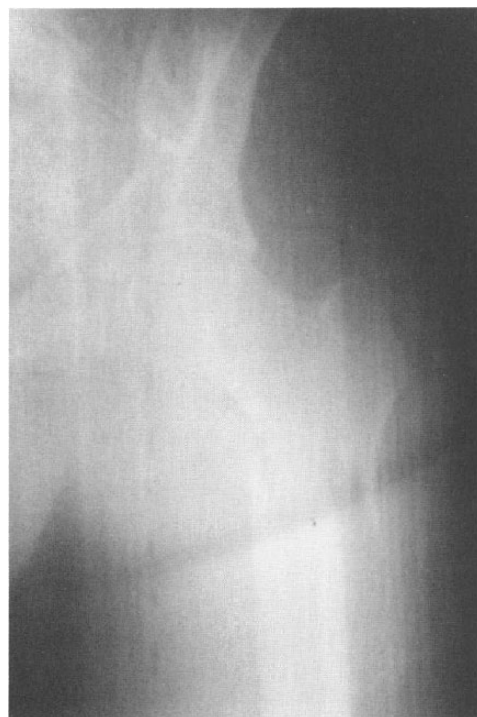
Injury radiograph.
